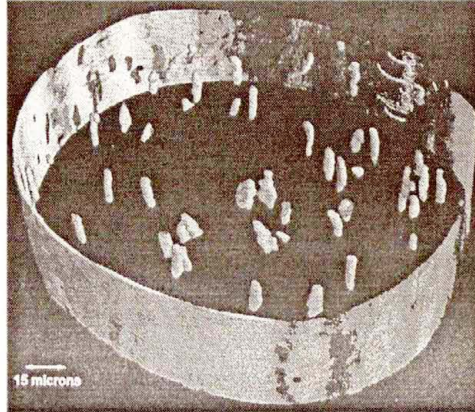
Edge-enhanced synchrotron CT of human trabecula exhibiting lacunae (Courtesy: Dr. M. Stampanoni, PSI, Switzerland).
